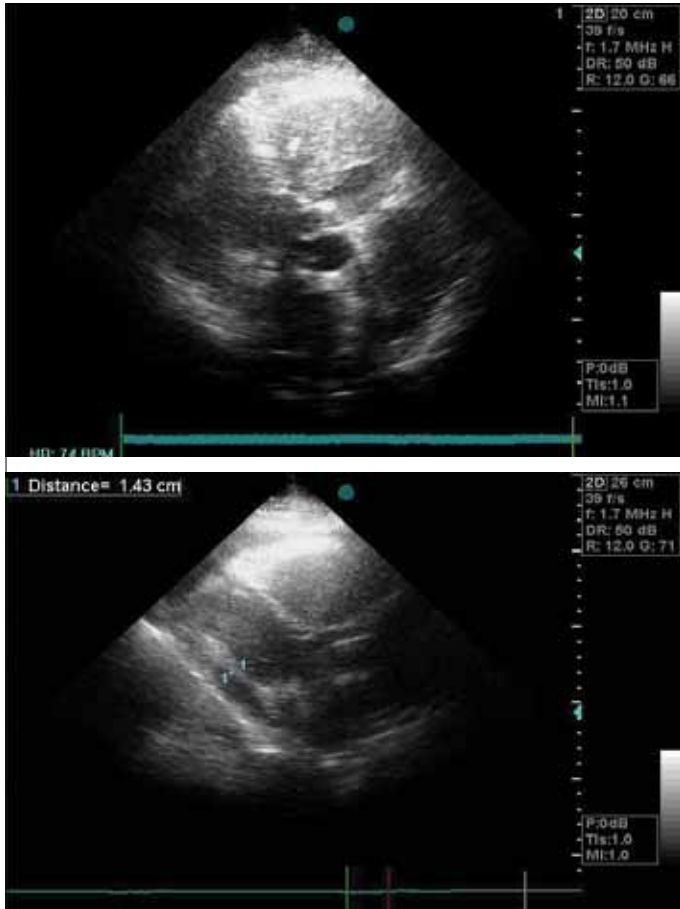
Transthoracic echocardiography view of a giant thrombus filling all right ventricle limiting blood flow
